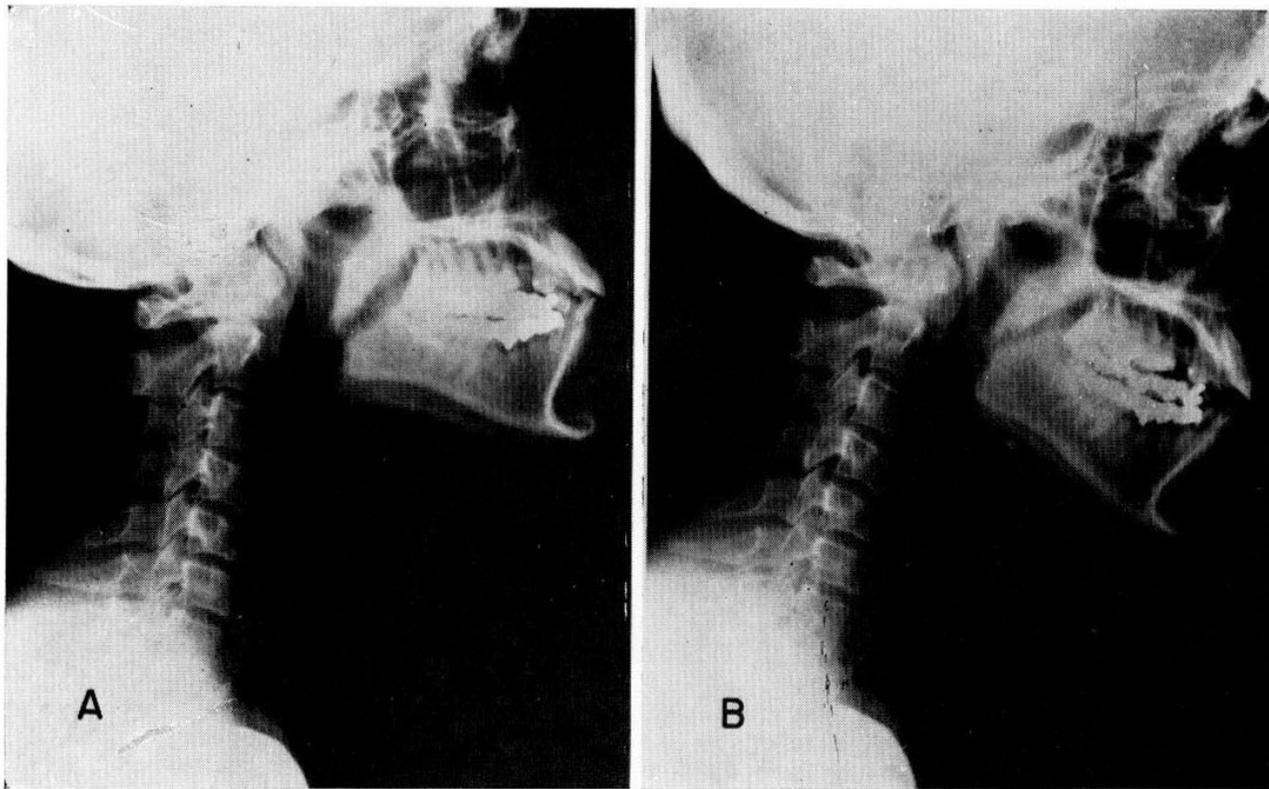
Changing the postural set, II: X-ray photographs showing differences in poise of the head in two erect sitting postures. A. Habitual. B. Experimental. (The x-ray photographs were obtained with the cooperation of Mr. Hal F. Knowlton of the Tufts University Health Services.)
